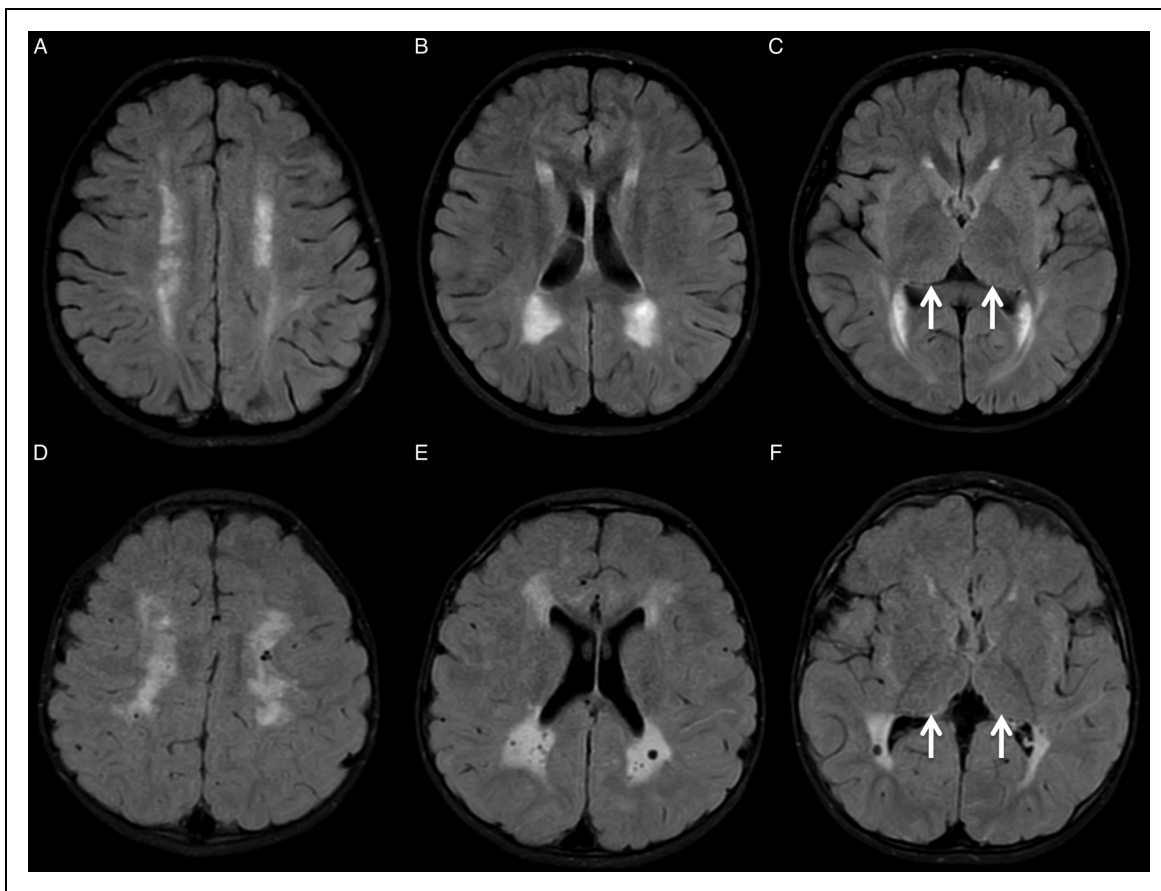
Cases with metabolic disorders. (A, B, C) A case of MNGIE syndrome in a 9-year-old and (D, E, F) a case of Lowe syndrome in a 3-year-old. Axial FLAIR (fluid-attenuated inversion recovery) images of both cases reveal hyperintense regions in the periventricular white matter and thalami with normal appearance (arrows). MNGIE, mitochondrial neurogastrointestinal encephalomyopathy.
